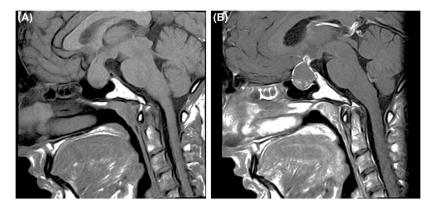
(Patient 2): Pre (A) and postcontrast (B) T1-weighted sagittal sequences document a solid and cystic lesion expanding the sella and extending to the third ventricle.
